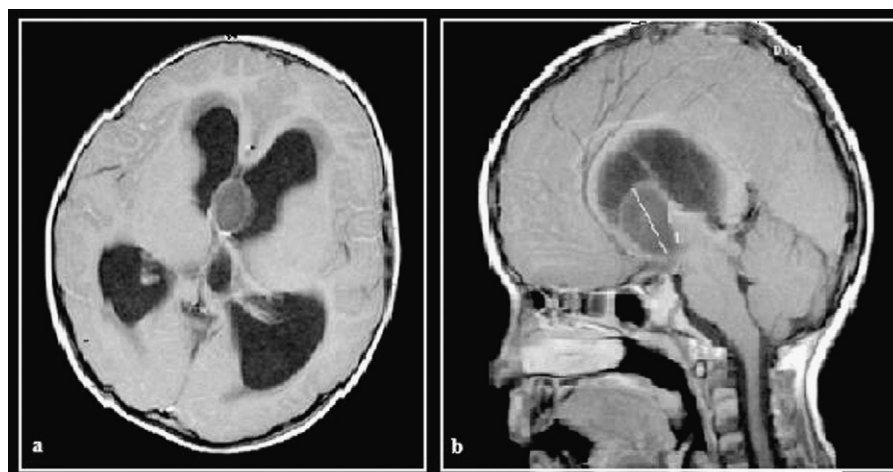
Gadolinium-enhanced spin-echo sequence MRI of the brain in (a) axial and (b) sagittal sections show no significant enhancement of the mass.
